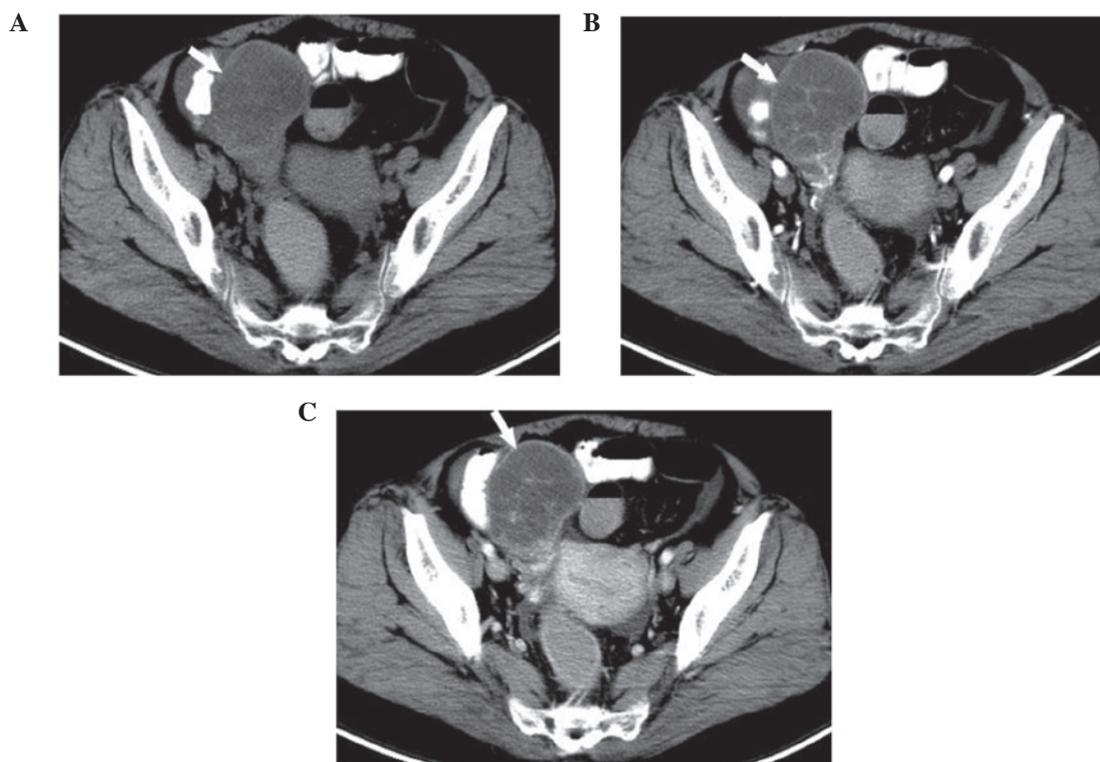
Sclerosing stromal tumor arising from the right ovary in a 59-year-old woman with a history of right-sided pelvic pain. (A) An ovoid solid-cystic mass was observed in the right adnexal area (white arrow). Plain CT values were 25-40 HU, with a mean value of 32.6 HU. (B) Dynamic contrast-enhanced CT scan revealed early septal enhancement in the center, and ring enhancement in the peripheral portion of the mass in the arterial phase (white arrow). The CT value of the solid component was ~132 HU. The CT value of the solid component was 125-140 HU, with a mean value of 132 HU (C) In the venous phase, the tumor demonstrated centripetal, progressive enhancement (white arrow). The CT values were 118-130 HU, with a mean value of 128 HU. The cystic areas of the tumor were observed. CT, computed tomography.
